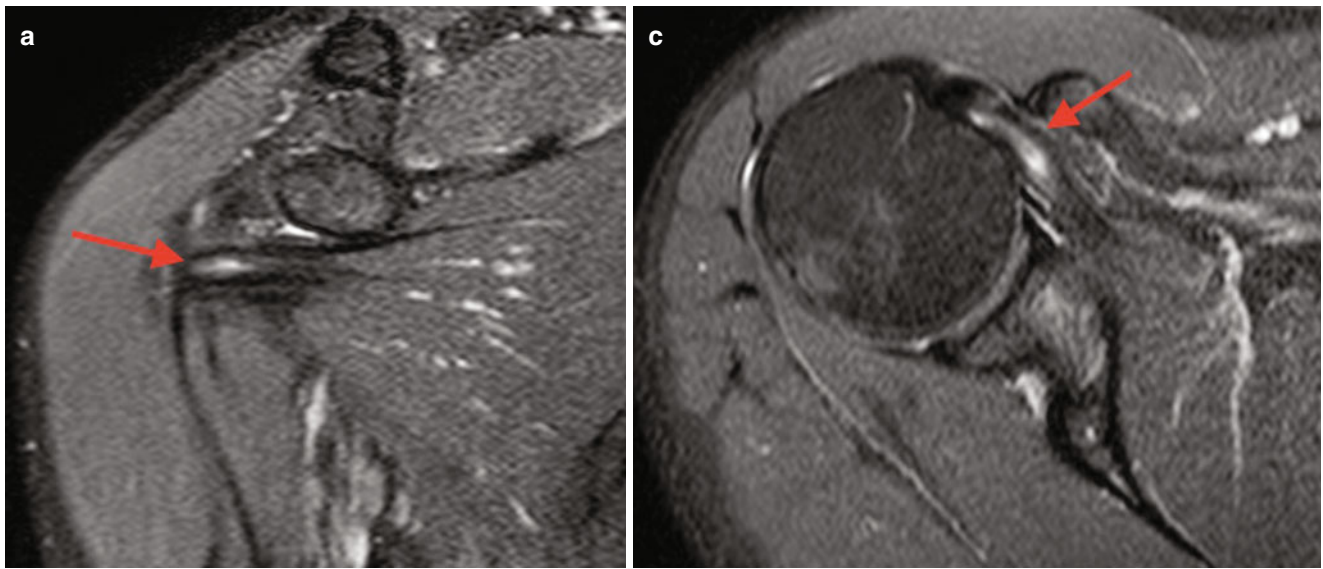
MRI of a right shoulder showing intralaminar lesion of subscapularis tendon (*red arrow*). (a) Coronal view; (b) axial view
